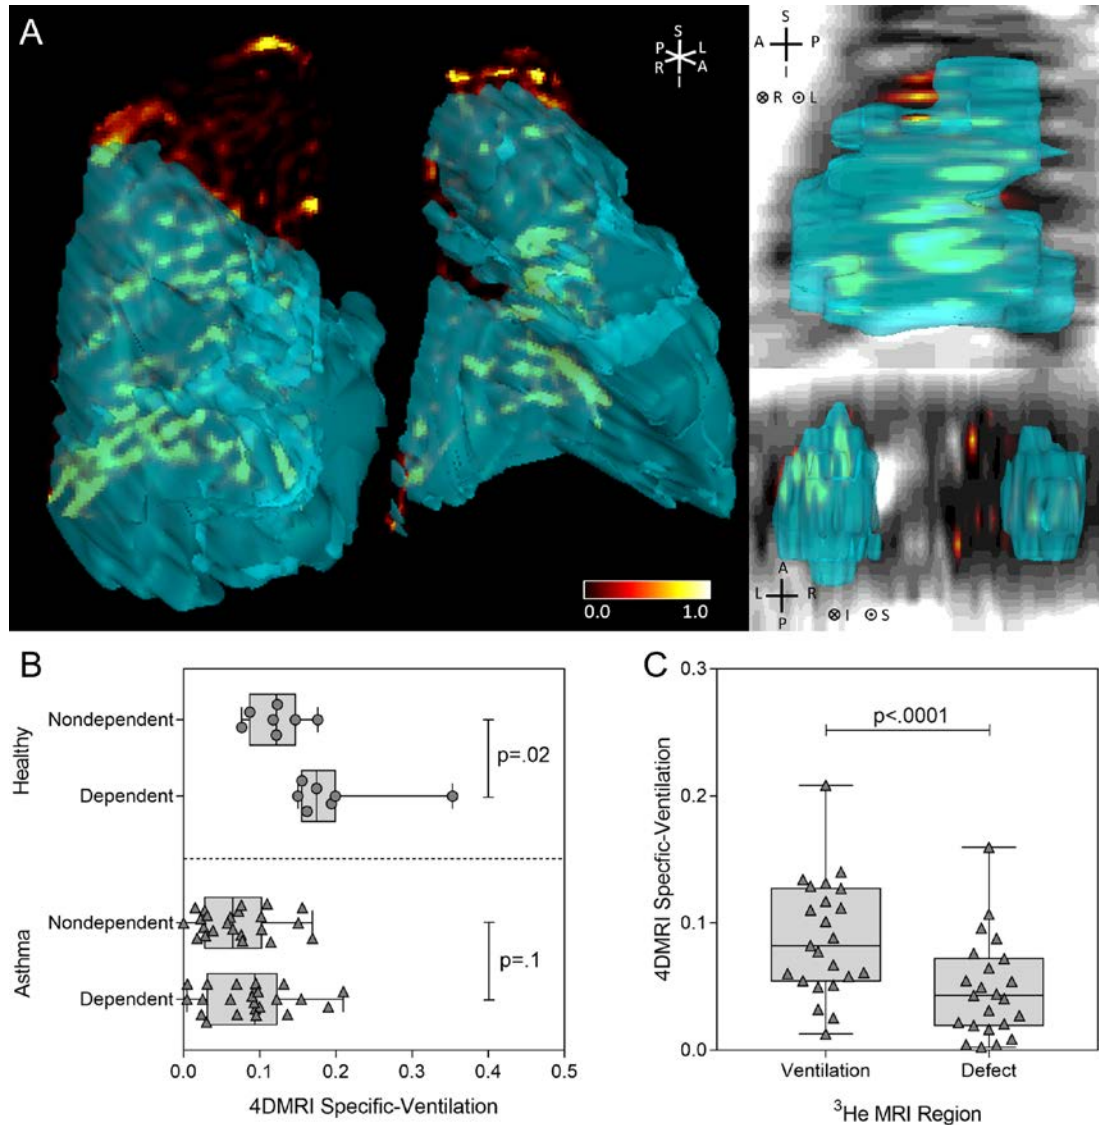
Spatial Correspondence of free-breathing 4DMRI Specific-Ventilation and ^3He MRI Static Ventilation Maps
